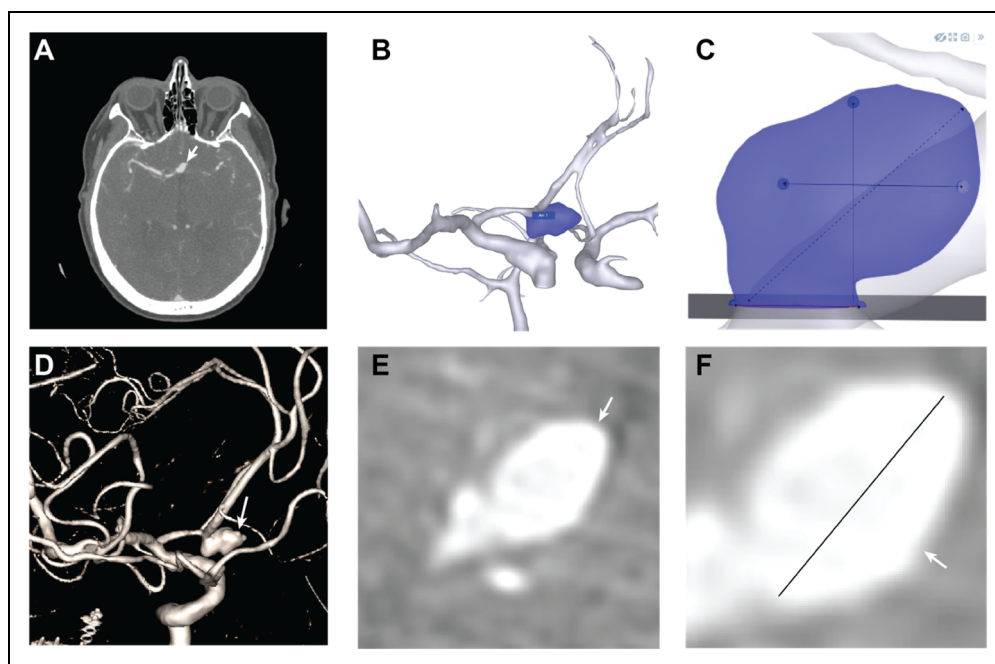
Representative case from a patient with a ruptured anterior communicating artery aneurysm. A 10.2 mm aneurysm arising from the anterior communicating artery is shown on CTA source images (A, arrow). RAPID Aneurysm correctly identified this aneurysm (B, purple shading) and automatically provided size measurements (C). 3D-DSA images (D-F) demonstrate the aneurysm on volumetric images (D, arrow) and 2D images in the anteroposterior (E, arrow) and lateral oblique (F, arrow) views. Reference standard measurements were derived from the 3D-DSA data (F, inset) and showed an excellent agreement with those generated by RAPID Aneurysm.
